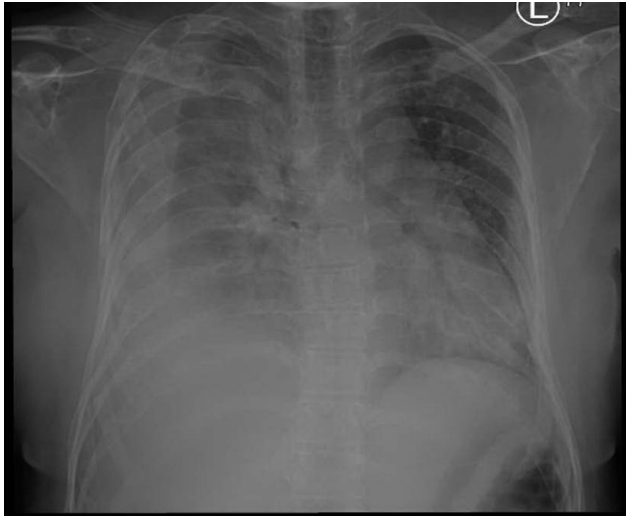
Chest X-ray revealing right-sided pleural effusion and multiple lytic lesions of the ribs and clavicle.
